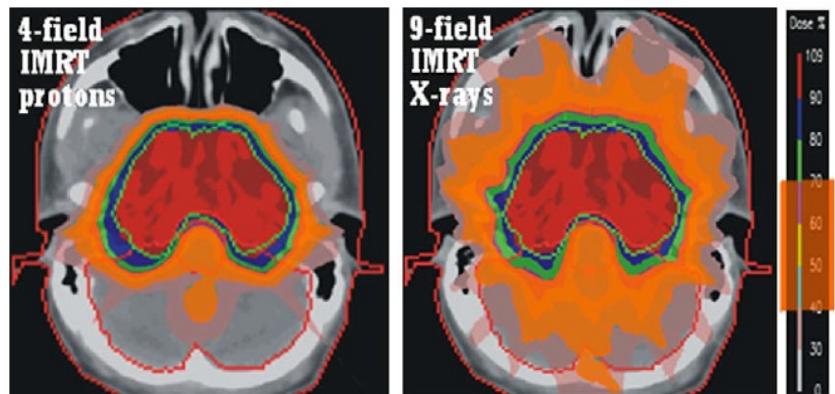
IMRT plans for protons (left) and X-rays (right). The area receiving between 40% and 70% of the prescribed dose (approximately 30–50 Gy) is shaded in orange. (Figure courtesy of A. Lomax, PSI.)
